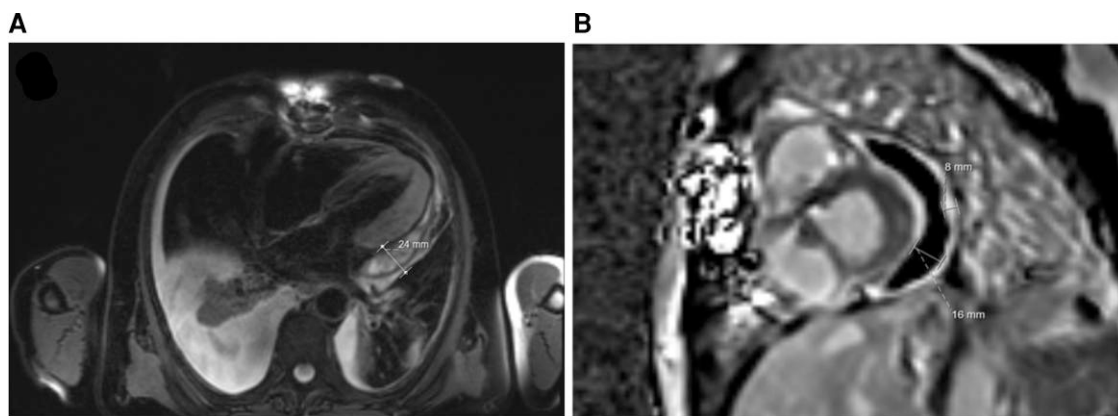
On T2 cardiac magnetic resonance imaging, thickened, fibrous crescent-shaped pericardial mass adjacent to the anterolateral, lateral, and inferolateral walls, measuring up to 24 mm (A). Phase Sensitive Inversion Recover sequences with gadolinium contrast demonstrated an 8 mm thick pericardium with up to 16 mm of pericardial fluid around the left ventricle (B). Evident interventricular dependence on free breathing module, indicative of constrictive physiology (Supplementary material online, Video).
